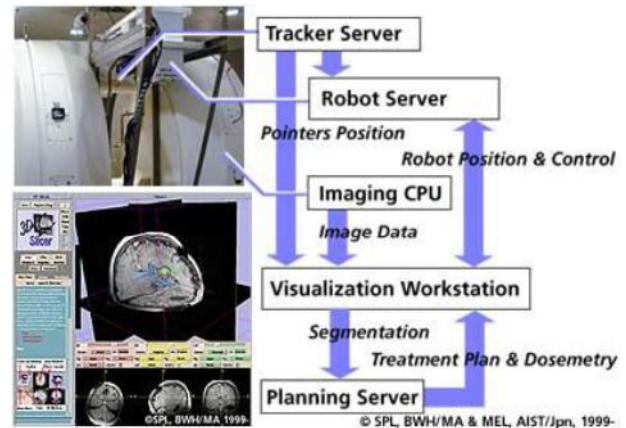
Model of MRI compatible robot
